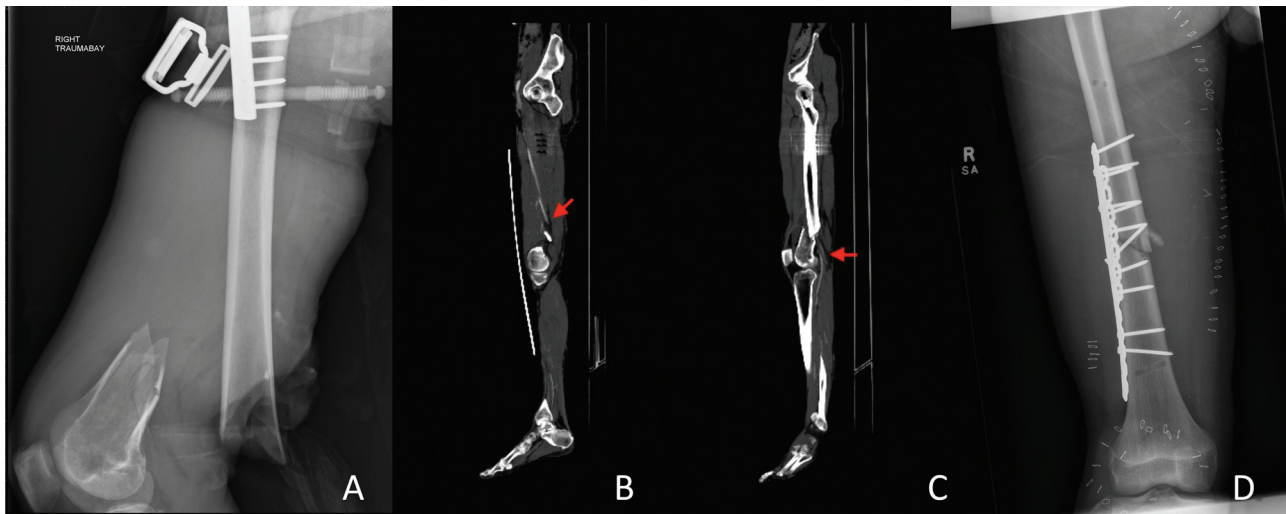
(A) Lateral radiograph of right femur performed in the trauma bay demonstrating type III C open distal femur fracture with vascular injury secondary to bicyclist versus motor vehicle crash. (B) CT angiogram sagittal images demonstrate traumatic injury involving the distal femoral and proximal popliteal arteries, (C) with reconstitution of flow distally at the level of the distal popliteal artery from collateral vessels. The injury was managed emergently with application of a knee spanning external fixator by orthopaedic surgery followed by femorotibial bypass and 4 compartment fasciotomies. (D) On postoperative day 1, the patient was taken back to the operating room for repeat I&D and open reduction internal fixation with a distal femoral locking plate.
